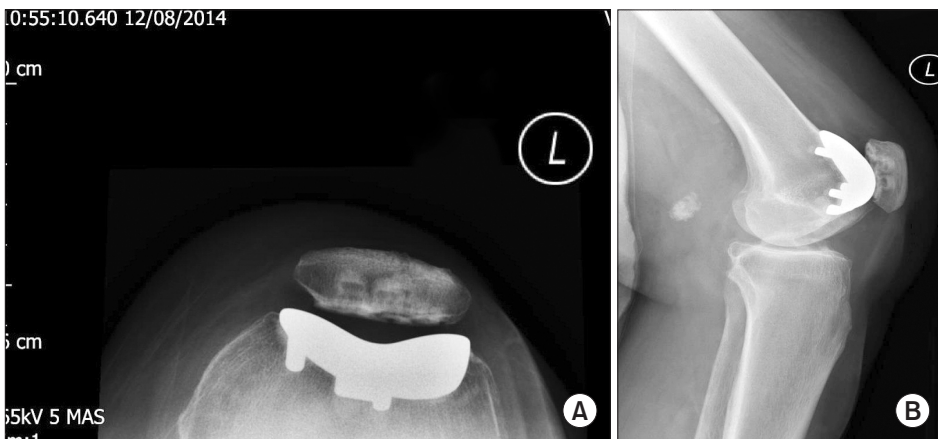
Postoperative radiographs following the Zimmer patellofemoral joint replacement: skyline view (A) and lateral view (B).
